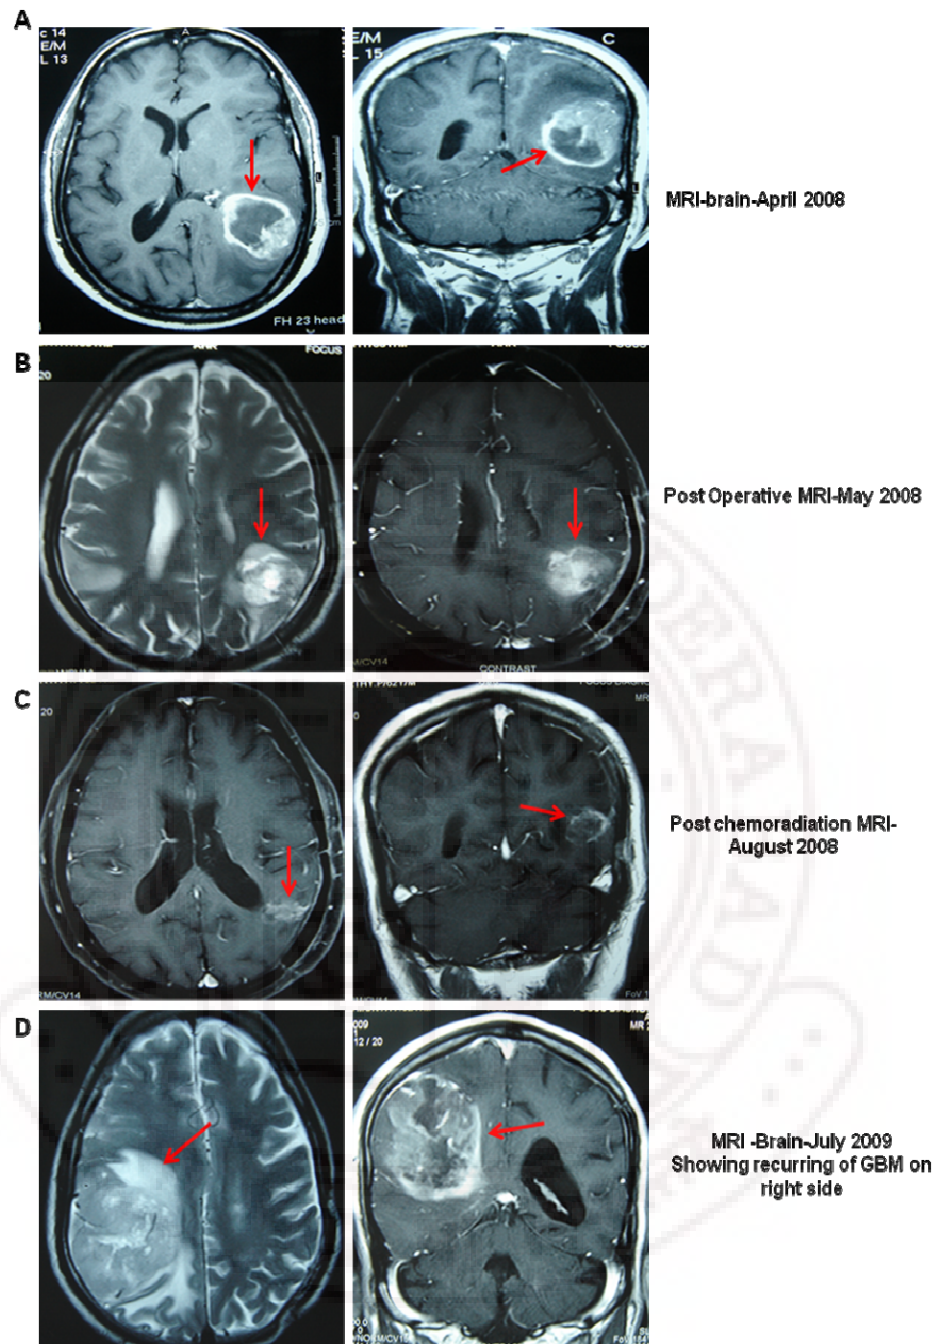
Recurring nature of GBM. A) MRI of patient diagnosed with GBM in April 2008 showing the tumor on left side of the brain. B) In May 2008, the post operative and post radiationtherapy MRI showing the resection of tumor. C) Then, in August 2008, post chemotherapy MRI showing great reduction in tumor size. D) After 11 months that is in July 2009 MRI showing the recurrence of tumor on right part of the brain with great increase in tumor mass. After, in August 2009 the patient was died.
